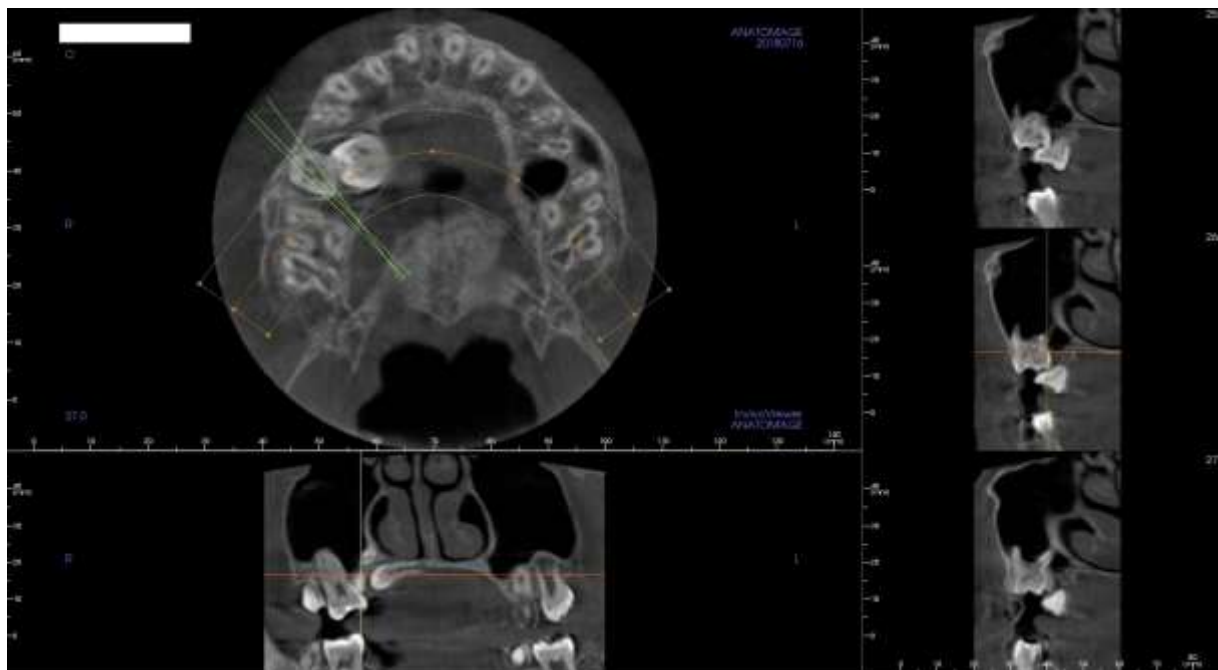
CT of the maxilla.
